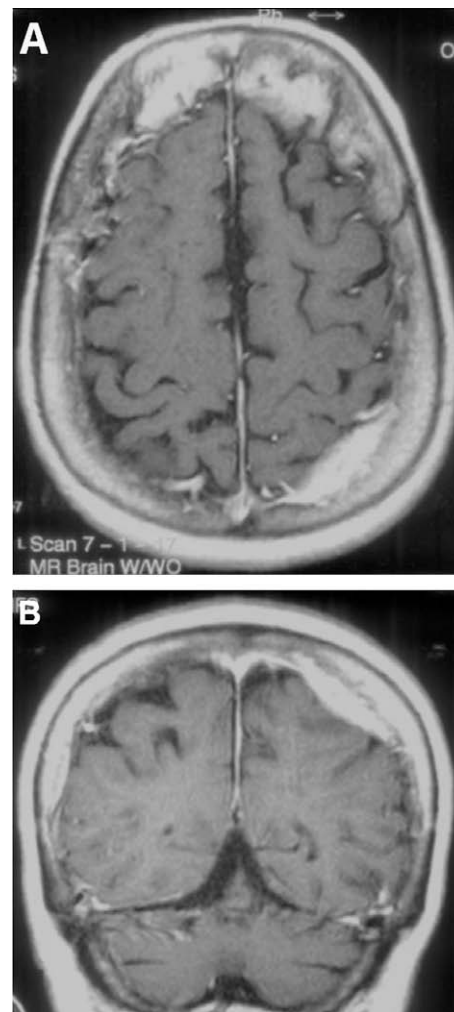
One-year postoperative (A) axial and (B) coronal T1-weighted MRI with contrast enhancement showing stable reduction in size of the left parietal lesion.
